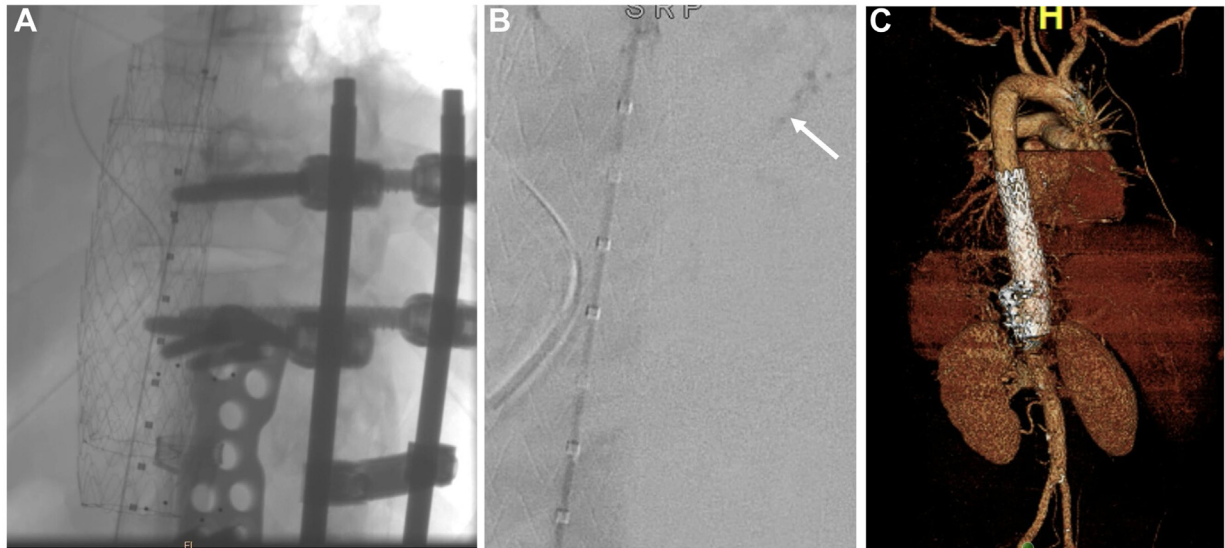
(A) Fluoroscopy depicting emergent Thoracic endovascular aortic repair (TEVAR) realignment and adjacent spinal hardware. (B) Pulmonary blush (arrow) during emergent TEVAR realignment. (C) Postoperative computed tomography three-dimensional rendering of TEVAR and spinal hardware.
